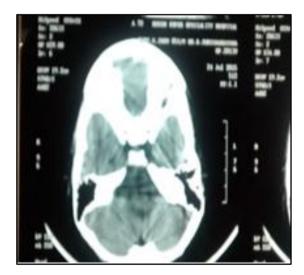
CT scan of Temporal bone of the child showing no significant pathology
